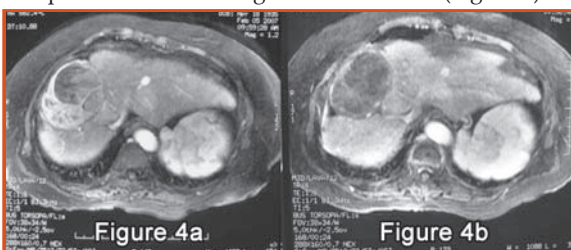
A 6.8 cm HCC in right lobe (Fig. 4a) treated with HIFU. Post-ablation MRI scan showed complete ablation (Fig. 4b).
